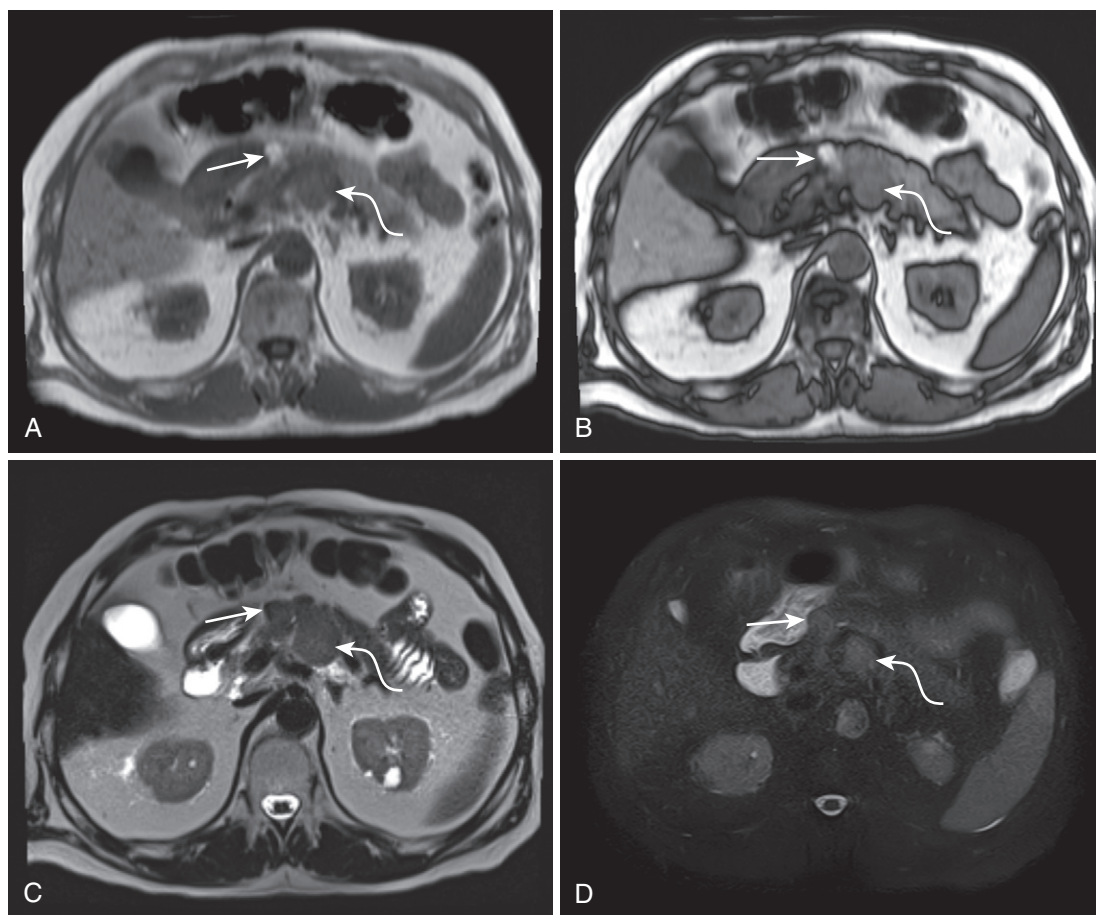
Pancreatic melanotic melanoma metastases. In-phase (A) and out-of-phase (B) T1-weighted gradient recalled-echo, T2-weighted (C) and fat-suppressed T2-weighted (D), and precontrast (E), arterial (F), and delayed (G) fat-suppressed T1-weighted gradient recalled-echo images of two pancreatic melanoma metastases. One of these metastases contains more melanin (*straight arrow*), increasing its T1-weighted signal intensity compared with the other lesion (*curved arrow*). Both metastases are slightly hyperintense to the pancreas on the T2-weighted images (more pronounced with fat suppression owing to increased dynamic range). The metastases demonstrate varied enhancement on postcontrast imaging.
